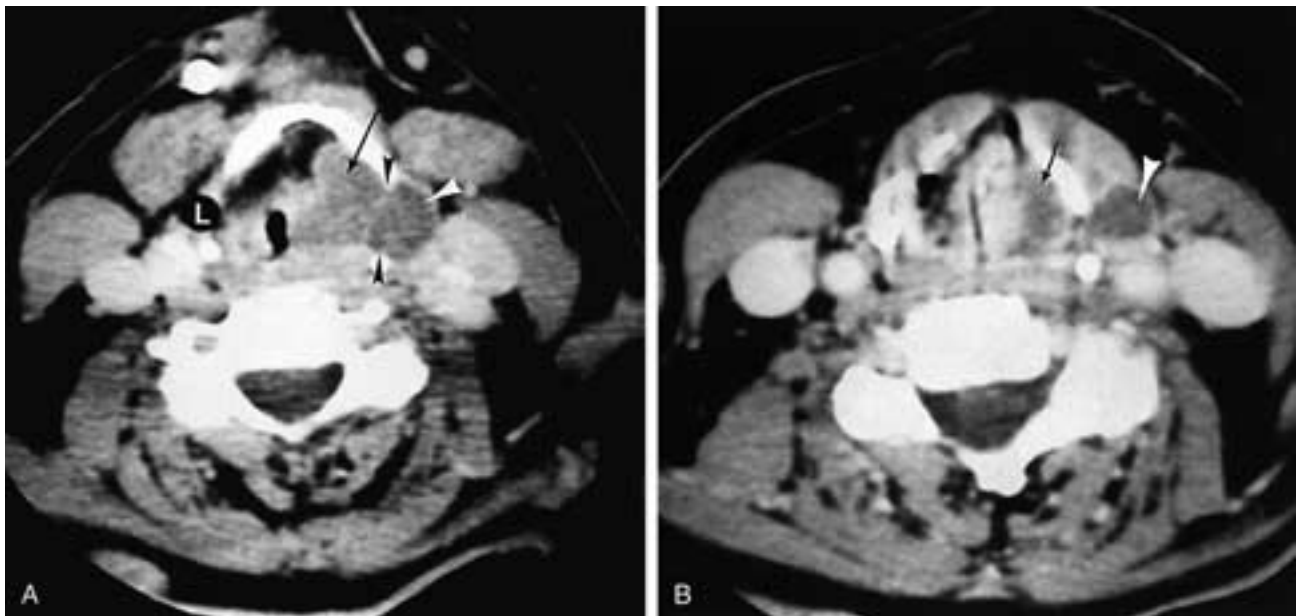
Axial CT of a laryngocele (saccular cyst). A, There is both an internal (*arrow*) and an external (*white arrowhead*) component. The position of the thyrohyoid membrane is signified by black arrowheads. A small air-filled external laryngocele (*L*) is seen on the opposite side. B, Lower scan through the supraglottic larynx shows the abnormality in the paraglottic space (*arrow*) and the external component (*arrowhead*).
